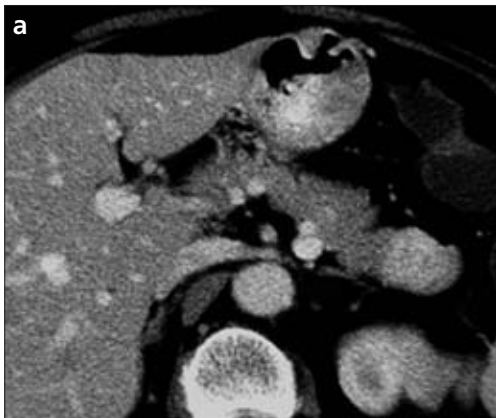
a–d. Multiple homogeneously enhancing metastases in the body and tail of the pancreas (CT images, a, b) with intermediate signal intensity on HASTE T2-weighted MR images (c, d) in a 77-year-old patient with right-sided renal cell carcinoma. Pancreatic metastases were detected 50 months after nephrectomy.
